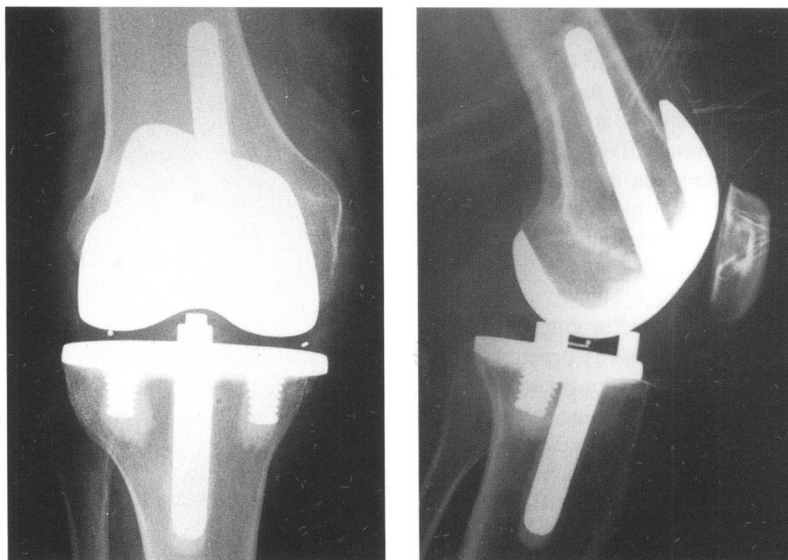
Anteroposterior (left) and lateral (right) radiographs of the prosthesis which were used to study radiolucency which was present in only 6% of 97 operated knees with a minimum follow-up of 5 years.
